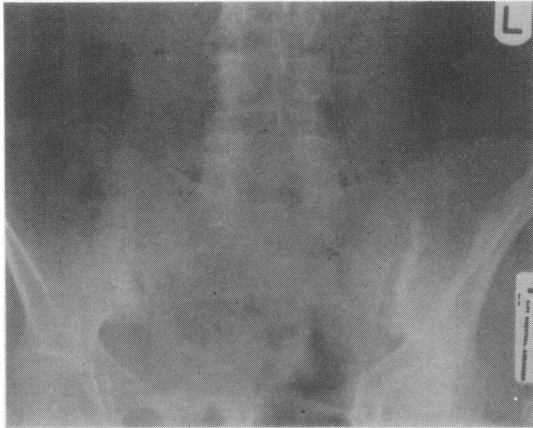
Radiograph of pelvis showing sacroiliitis and lumbar syndesmophytes.
